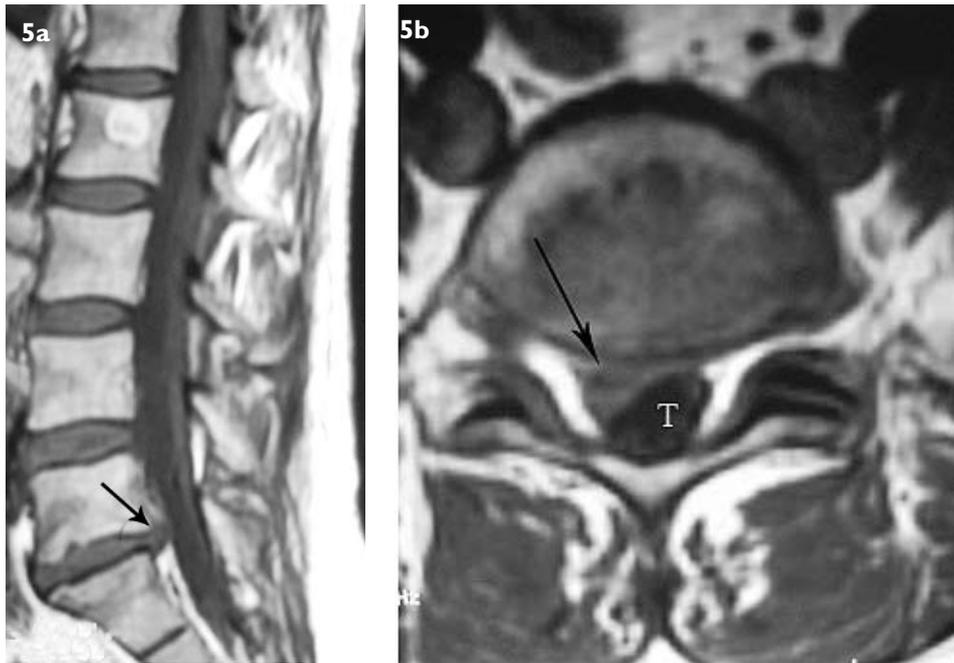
(a) Sagittal and (b) axial T1-W MR images show a right paracentral disc extrusion (arrow) associated with moderate thecal sac (T) impression at L5-S1 level.
